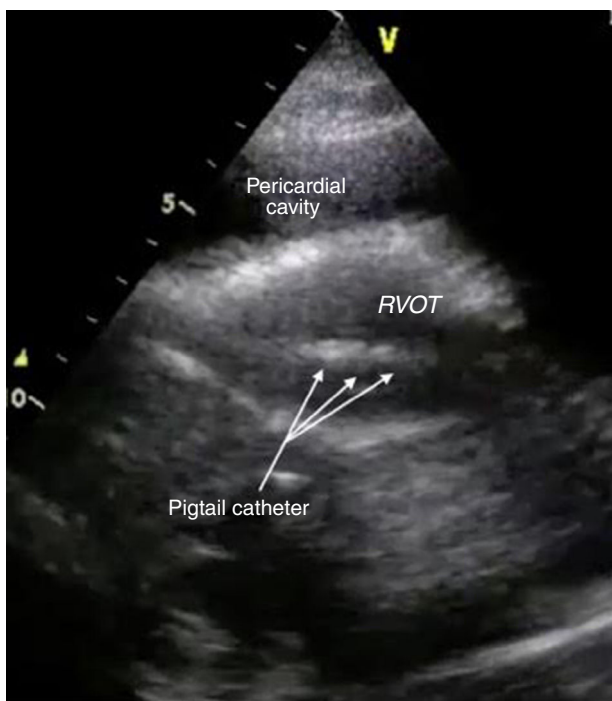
Long-axis parasternal transthoracic echocardiographic view showing the pigtail catheter in the right ventricle. RVOT: right ventricular outflow tract.
